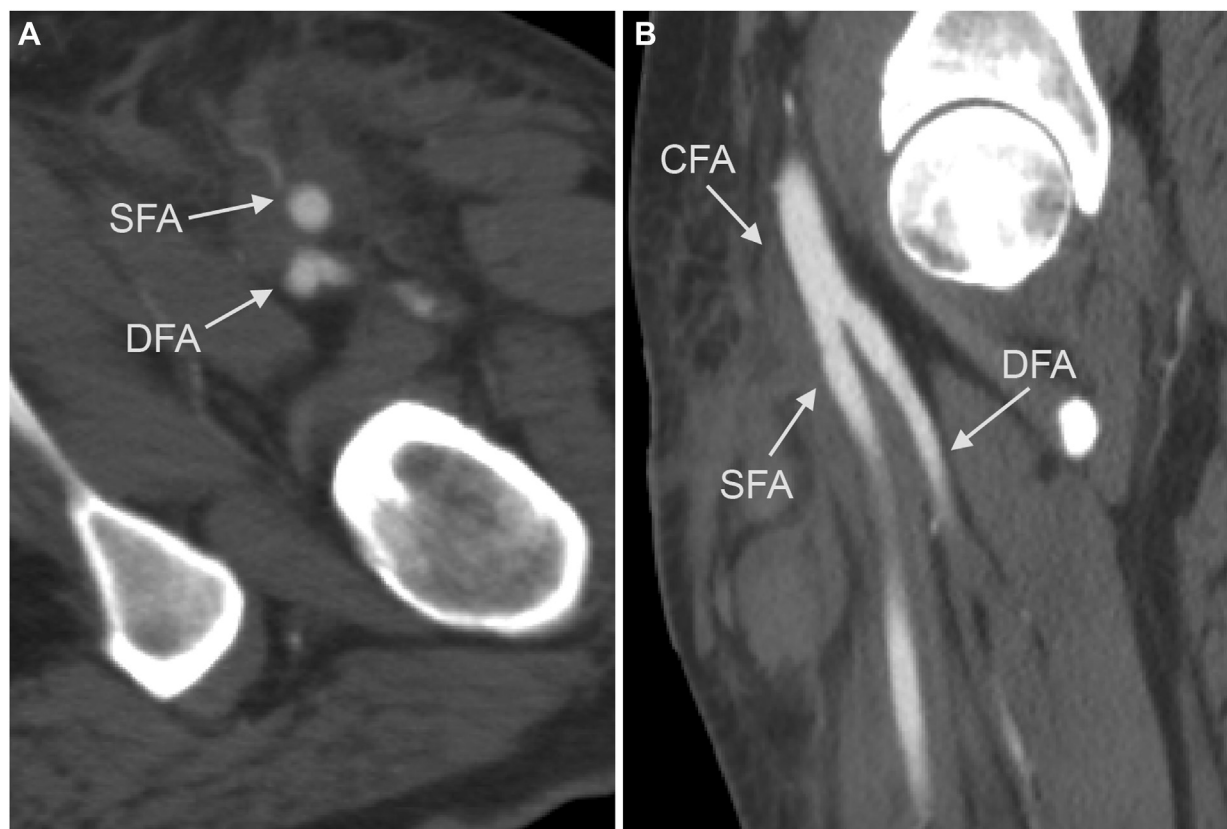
Axial (A) and sagittal (B) postoperative contrast-enhanced computed tomography views showing successful closure of the pseudoaneurysm. CFA, Common femoral artery; DFA, deep femoral artery; SFA, superficial femoral artery.
